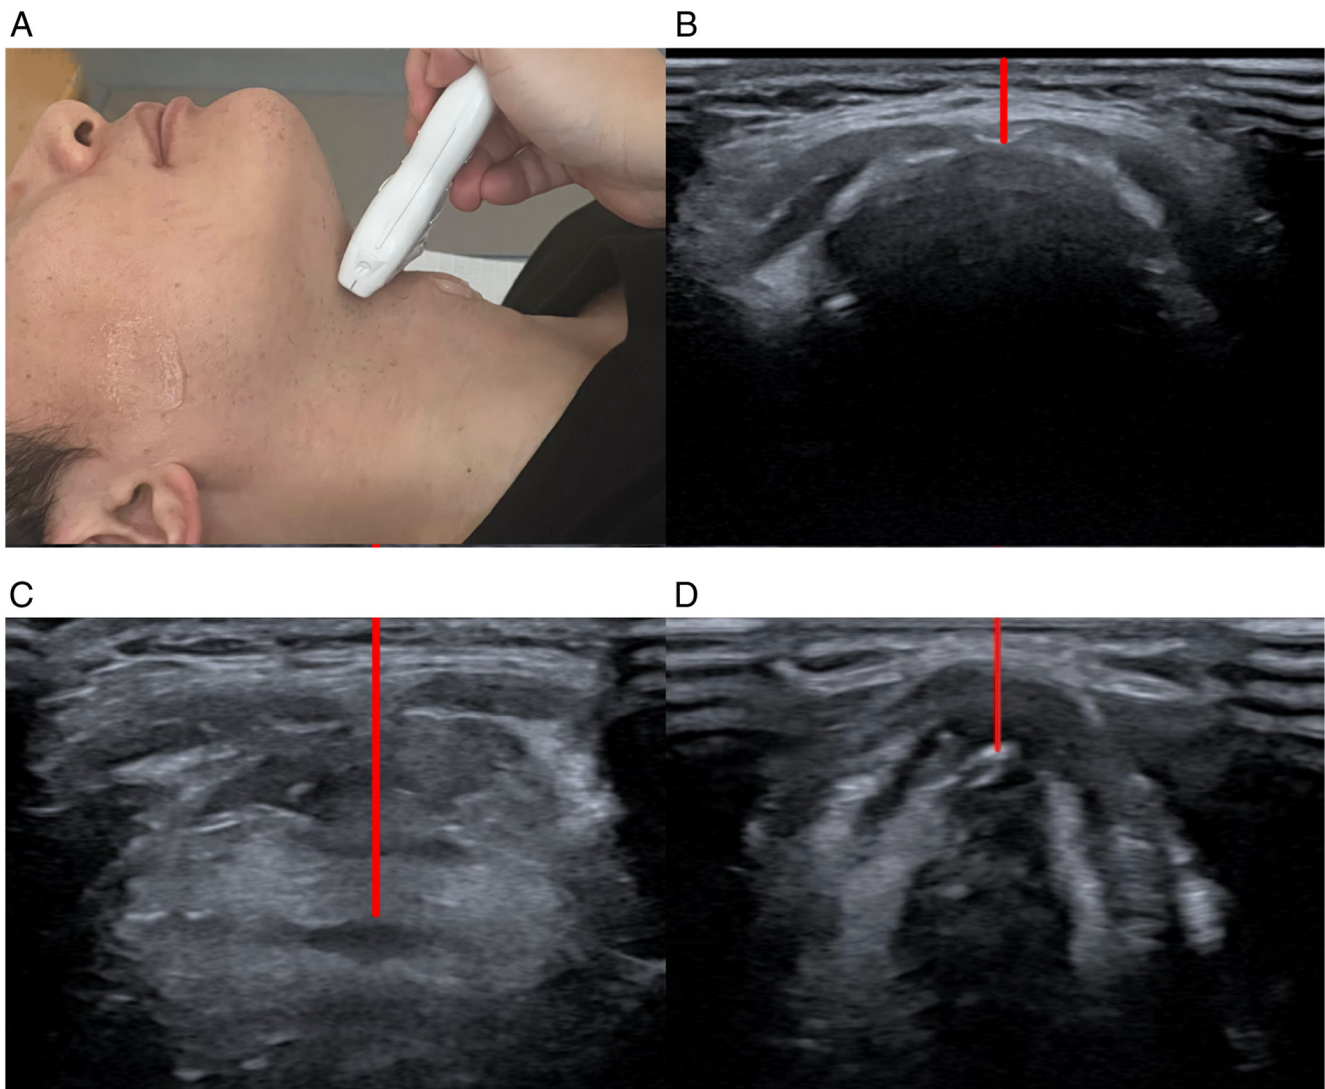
Ultrasound measurement of anterior neck airway parameters using a high-frequency linear array probe. (A) Placement of the high-frequency linear array probe on the anterior neck. (B) the distance from the skin to the hyoid bone (the red line), (C) the distance from the skin to the epiglottis (the red line) and (D) the distance from the skin to the anterior commissure of the vocal cords (the red line).
